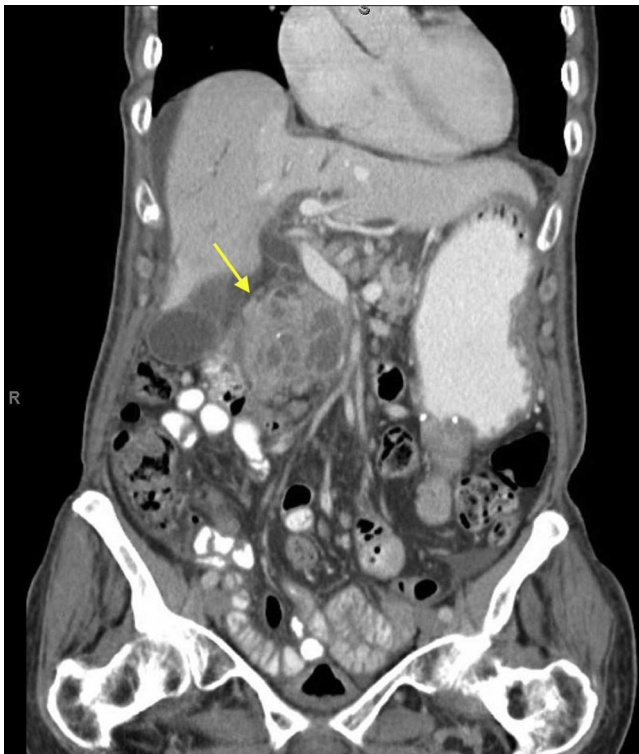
Contrast-enhanced CT view of abdomen showing soft-tissue mass in the duodenum causing gastric outlet obstruction.
